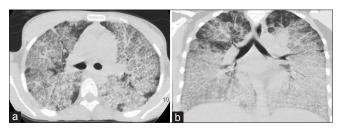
High-resolution computed tomography chest (a) (lung window) and (b) (coronal section). The anterior part of both the lung fields show typical crazy-paving pattern with central ground-glassing and peripheral interlobular septal thickening. In the dependent part of the lung, there is an increased density secondary to the gravitational accumulation of lipo-proteinaceous fluid
